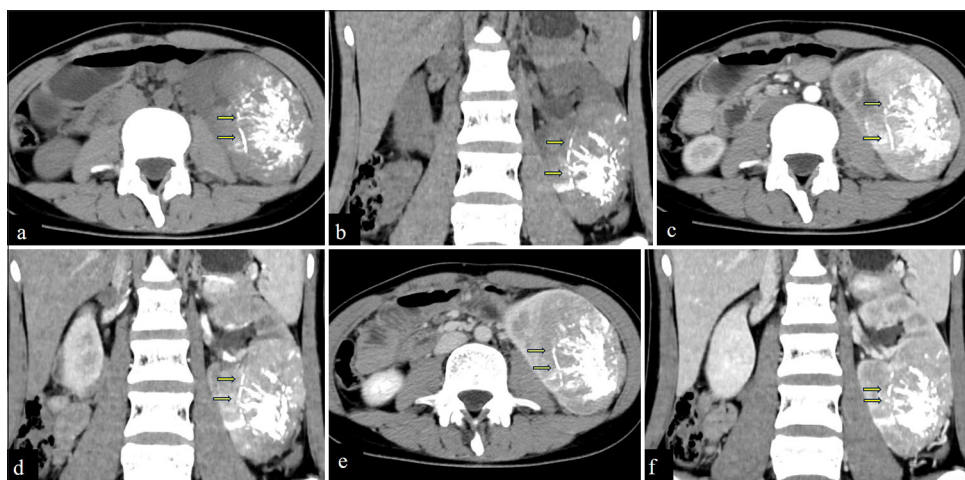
A 20-year-old female patient presented with left-sided lumbar and lower abdominal pain. (a and b) Noncontrast computed tomography (CT) scans show a markedly enlarged, dysmorphic left kidney with a slightly hyperdense soft-tissue mass in the mid-to-lower poles. The lesion contains diffusely distributed patchy and punctate calcifications, solid high-attenuation foci, and intermittent arcuate calcified shadows (yellow arrows). (c and d) Cortical-phase contrast-enhanced CT images demonstrate pronounced heterogeneous enhancement of the lesion's parenchymal component, exceeding the enhancement of the upper pole renal parenchyma. Tortuous intralesional vessels, deep lobulation, and both well-defined and ill-defined margins are visible. The left renal pelvis and collecting system are mildly dilated. Enhancement of the remaining upper-pole parenchyma is significantly lower than that of the tumor and the contralateral kidney (yellow arrows). (e and f) Medullary-phase contrast-enhanced CT images reveal persistent, marked enhancement of the lesion's parenchyma, with attenuation lower than the upper-pole cortex but higher than the medulla (yellow arrows). (The yellow arrows indicate the calcified shadows.)
